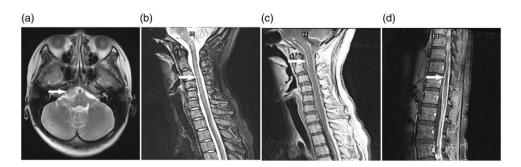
Follow-up magnetic resonance images of the brain and spinal cord of a 20-year-old female patient that presented with a 3-month history of daily persistent headaches that deteriorated at night. The original nodular lesion (arrow) in the right prepontine cistern was enlarged with similar radiological features compared with the initial images (a). Sagittal T2-weighted imaging revealed slightly blurry plaques without gadolinium enhancement (arrow) in the cervical cord (b, c). Diffuse gadolinium enhancement (arrow) in the spinal meninges of the cervical, thoracic and lumbar cord was found (c, d).
